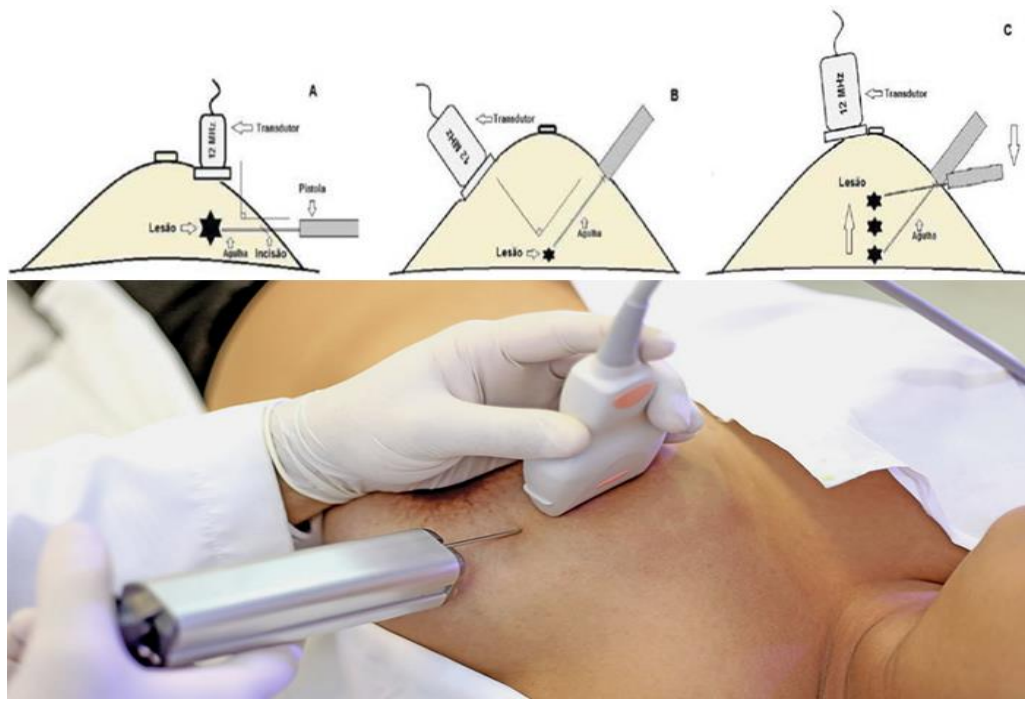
Ultrasound guided Tru-cut biopsy
